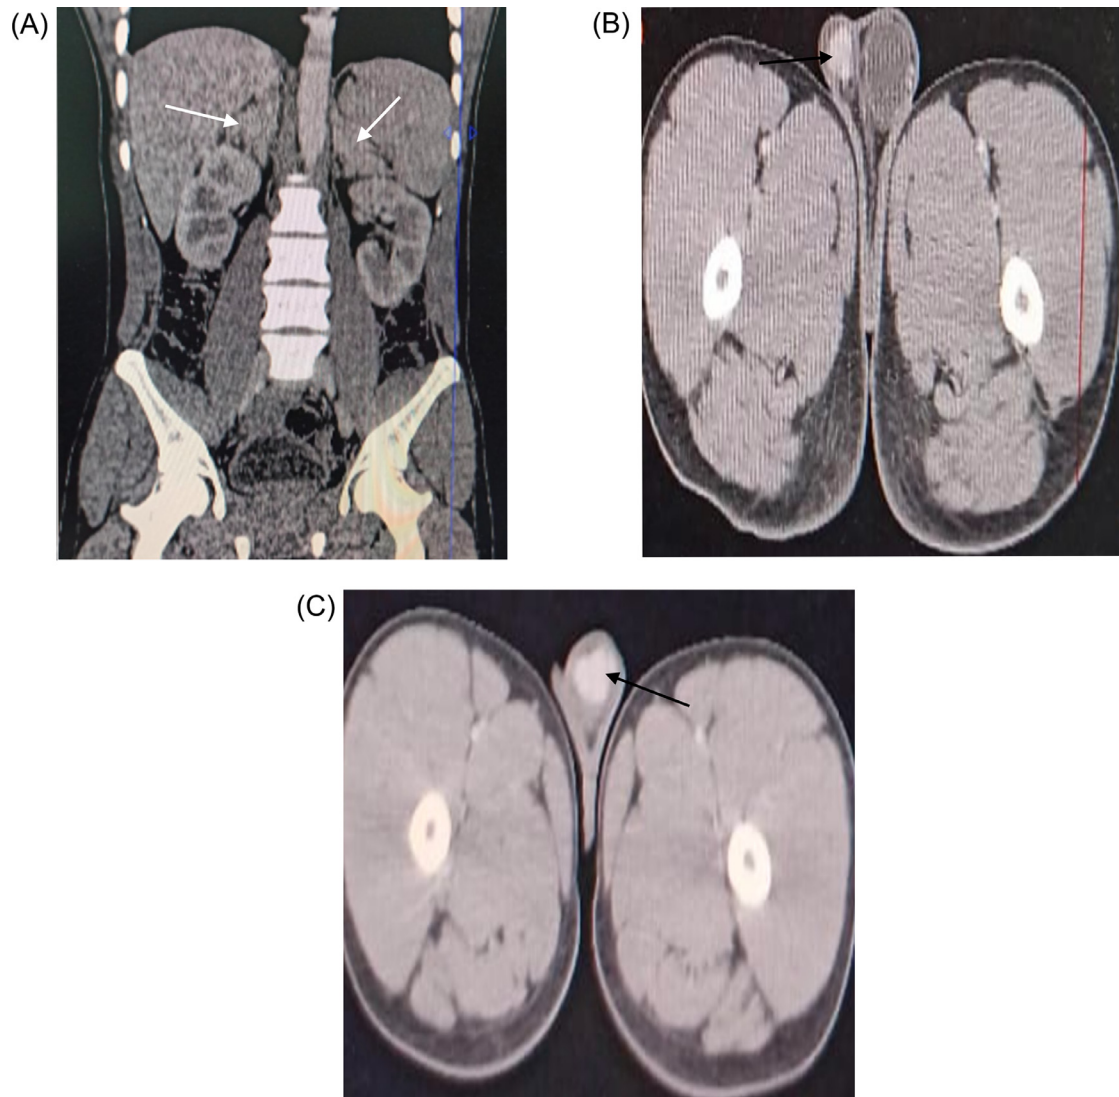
(A) Contrast enhanced computed tomography (CECT) image of abdomen in coronal reformatted section showing bilateral adrenal hyperplasia (White arrows). (B) CECT pelvis axial section showing multiple enhancing nodules in the right testis (black arrow). (C) CECT pelvis axial section showing multiple enhancing nodules in left testis (black arrow).
